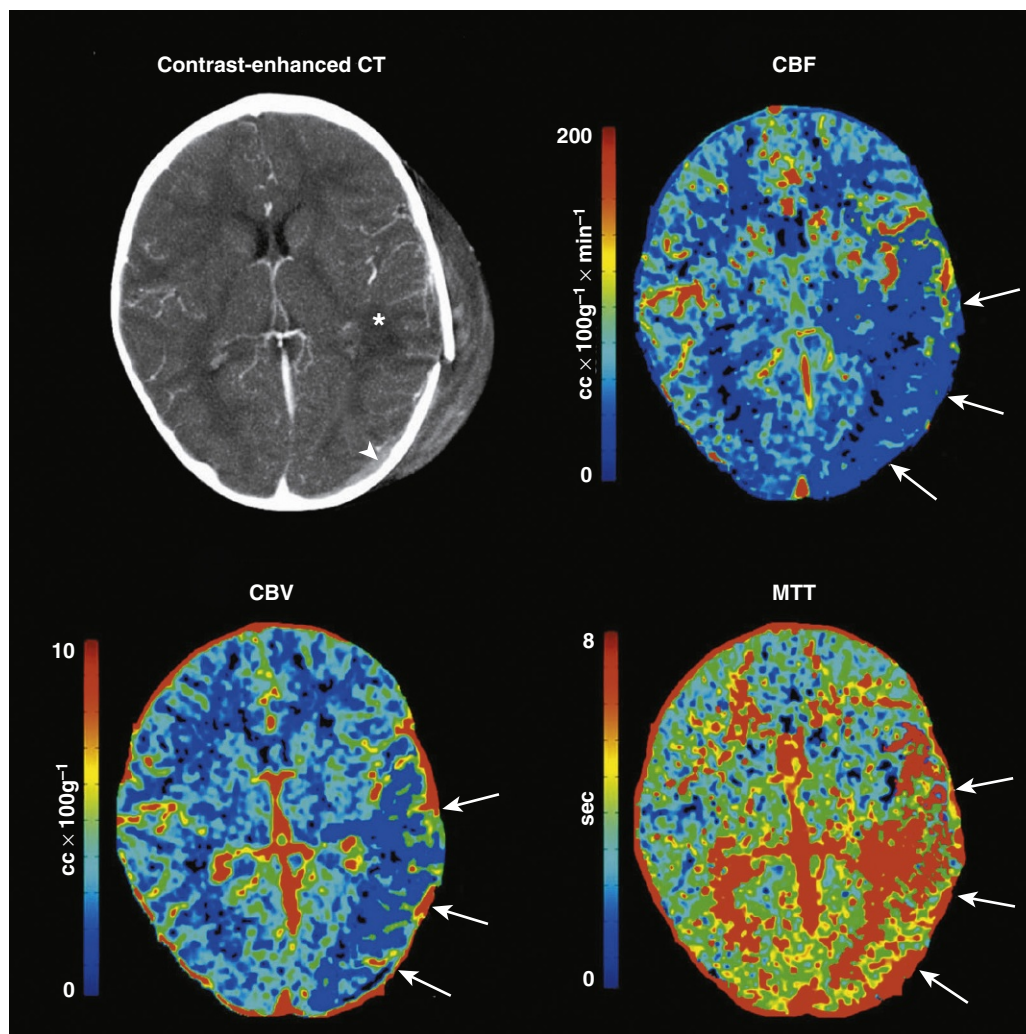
A patient who has fallen from a 6-m height, admitted with a Glasgow Coma Scale score of 9. Neurological examination in the emergency room revealed an asymmetry of tone and deep tendon reflex involving both right upper and lower limbs. Admission contrast-enhanced cerebral computed tomography (CT) demonstrated a displaced left parietal skull fracture, associated with a large cephalhematoma. A small left parieto-occipital epidural hematoma (white arrowhead) and a small contusion area (white star) could also be identified on the conventional CT images. Perfusion-CT (PCT) demonstrated a much wider area of brain perfusion compromise (white arrows), with involvement of the whole left temporal and parietal lobes, the latter showing increased mean transit time (MTT) and decreased cerebral blood flow (CBF) and volume (CBV). Thus, PCT afforded a better understanding of the neurological examination findings on admission than conventional CT.
